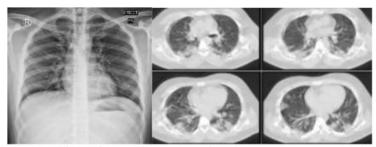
A. A chest X-ray and an axial CT image in a 27-year-male moderate common type patient (5 days from symptom onset to chest X-ray and CT scan) reveals multiple GGO in both lungs.
